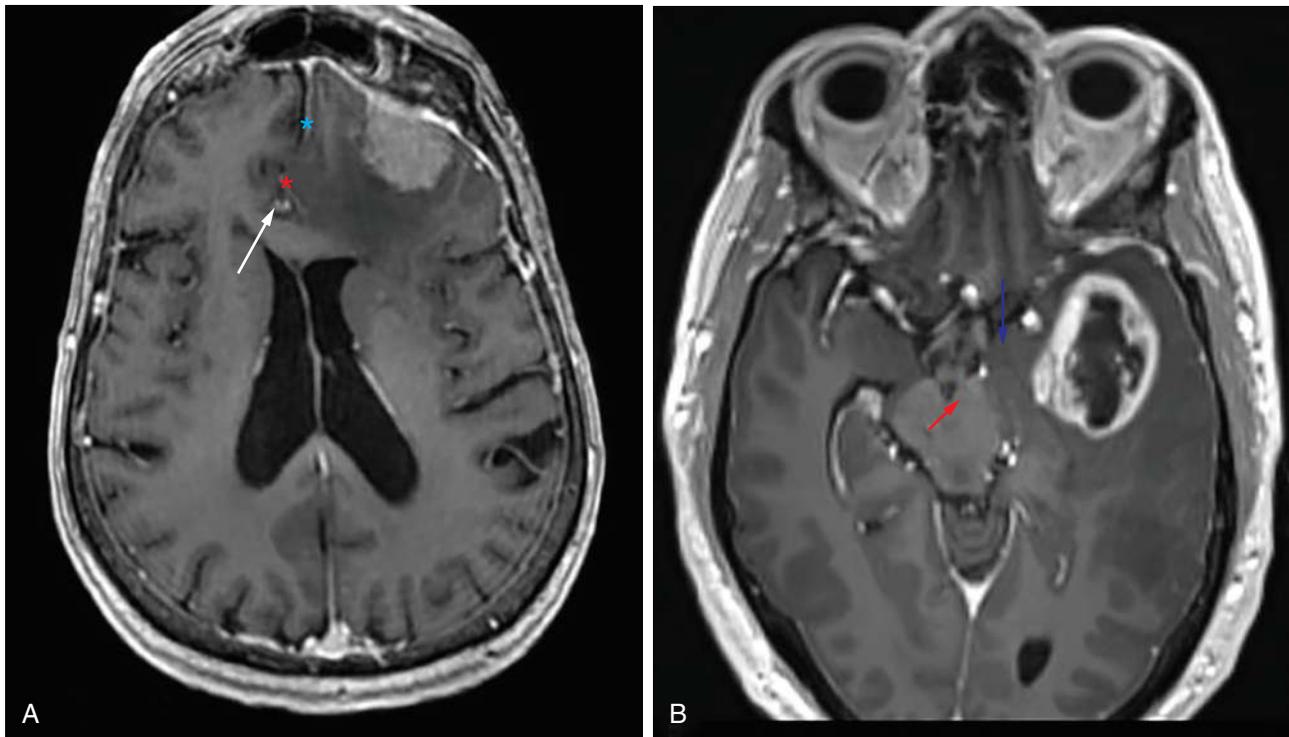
Subfalcine and downward transtentorial herniation. A, T1-weighted image with contrast shows herniation of the left cingulate gyrus (*red asterisk*) under the inferior margin of the falx cerebri (*blue asterisk*) in this patient with a left frontal meningioma. Note deviation of the anterior cerebral arteries to the right (*white arrow*), placing them at risk for injury. B, T1-weighted image with contrast shows downward herniation of the left uncus over the tentorium (*blue arrow*) in this patient with high-grade glioma, causing compression of the ipsilateral cerebral peduncle (*red arrow*).
